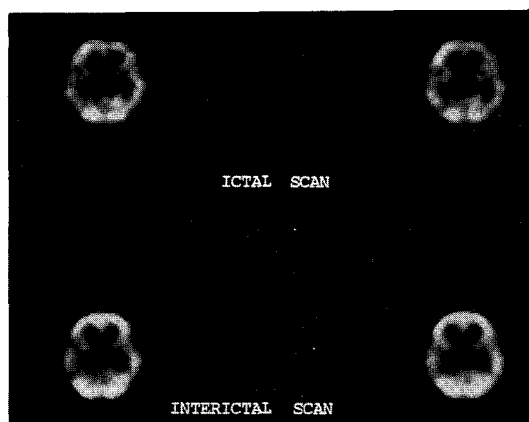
Ipsilateral frontal lobe propagation. Right temporal epilepsy in a 11-year-old male. Ictal SPECT shows increased uptakes on right frontal lobe, and interictal SPECT shows decreased uptake on the same site.
